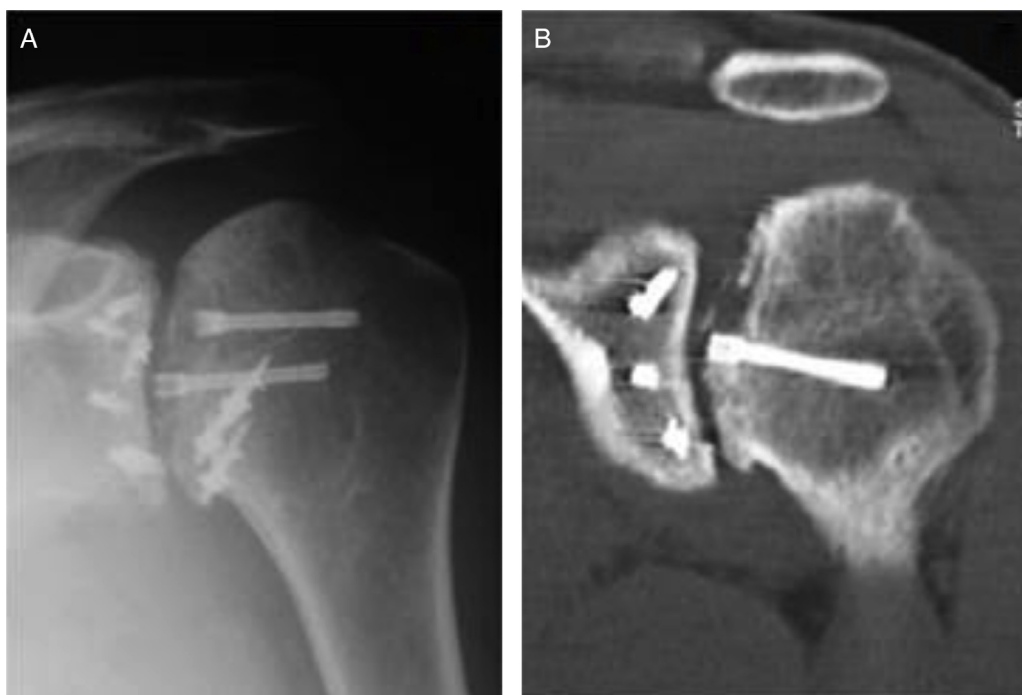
(A) Radiographic image of the left shoulder in anteroposterior view, showing graft resorption and subchondral collapse, with protrusion of one of the screws, six months after articular reconstruction surgery of the humeral head; (B) coronal computed tomography image (bone window) of the same shoulder, demonstrating the articular protrusion of the screw in greater detail.
